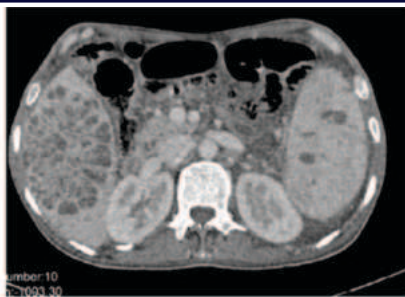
Portal Venous Phase acquisition of the Triple phase CT scan in the same patient shows enhancement of the walls of multiple small cystic internal structures.
